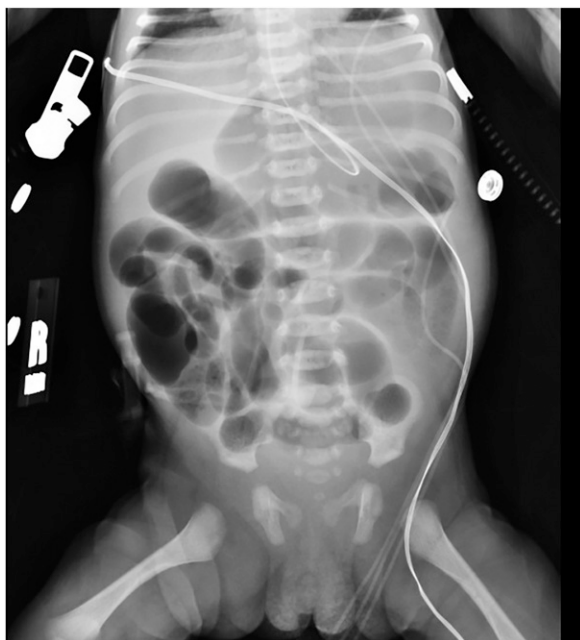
Small bowel obstruction noted on repeat kidney, ureter, bladder radiograph.
